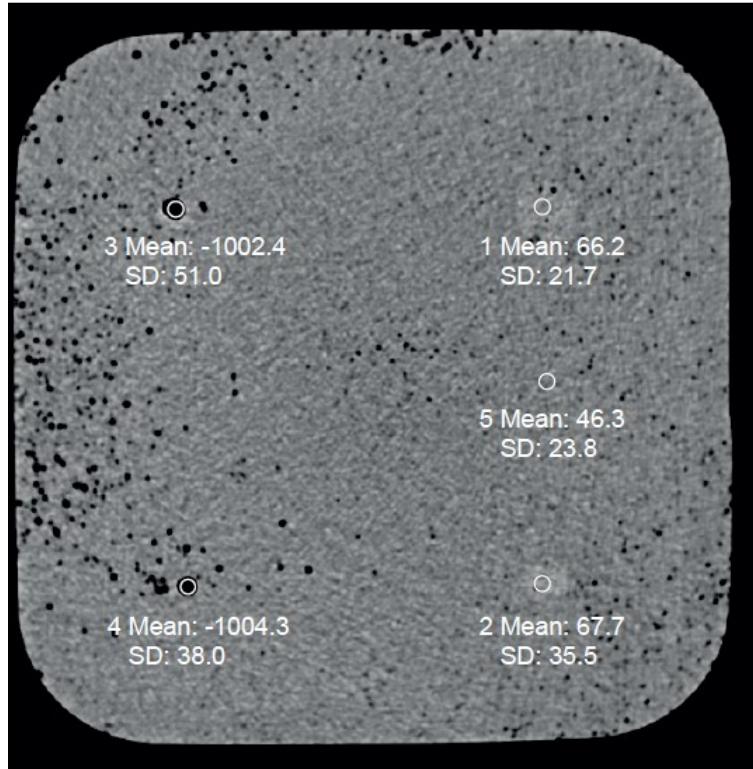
2-D slice through the volumetric CT image showing the CT number at the locations of the inclusions.
